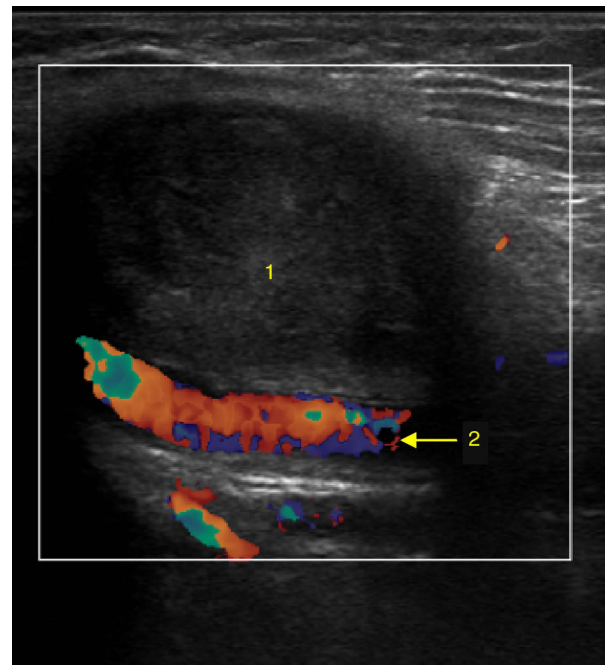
CTA showing the pseudoaneurysm of the right superficial femoral artery (1). It is possible to identify the haemodialysis catheter in the common femoral vein (2).
